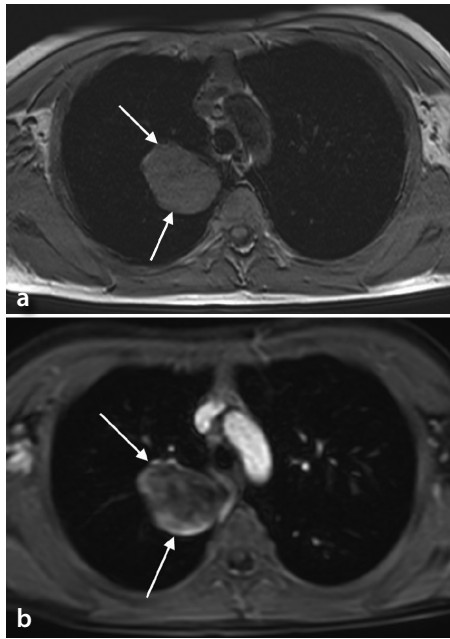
(a, b) A nine-year-old boy diagnosed with lung adenocarcinoma. (a) The axial T1-weighted image shows a well-circumscribed and isointense tumor in the right upper lobe (arrow). (b) Note the heterogeneous enhancement on the T1-weighted post-contrast image (arrow).
